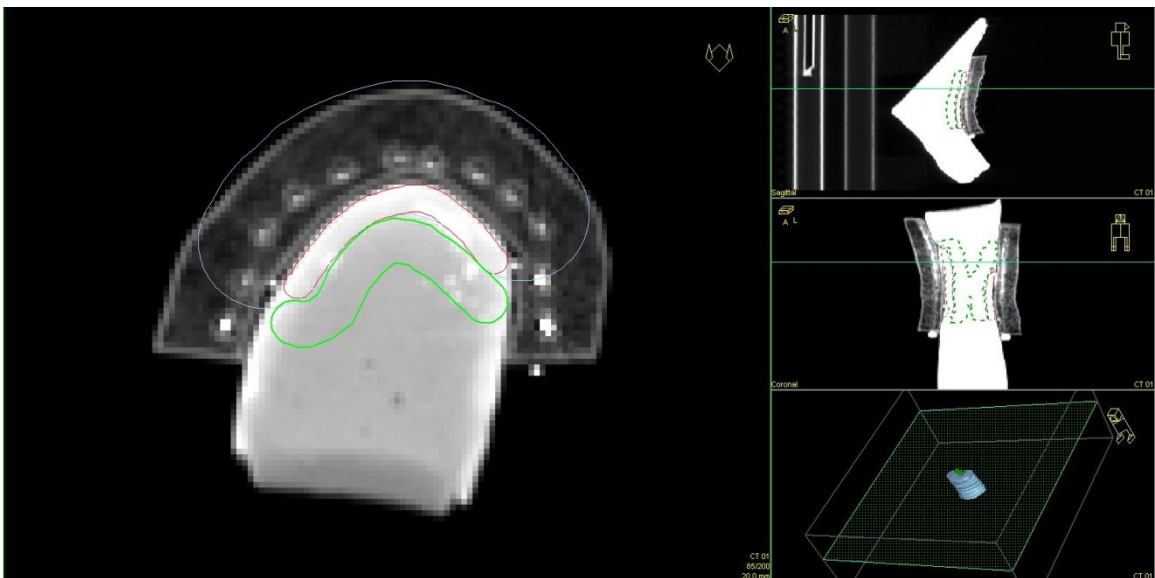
View of the contoured CTV (red), an OAR (green), PTV (white), and the x-ray dummy sources within the 3D printed applicator in Oncentra Brachy.
